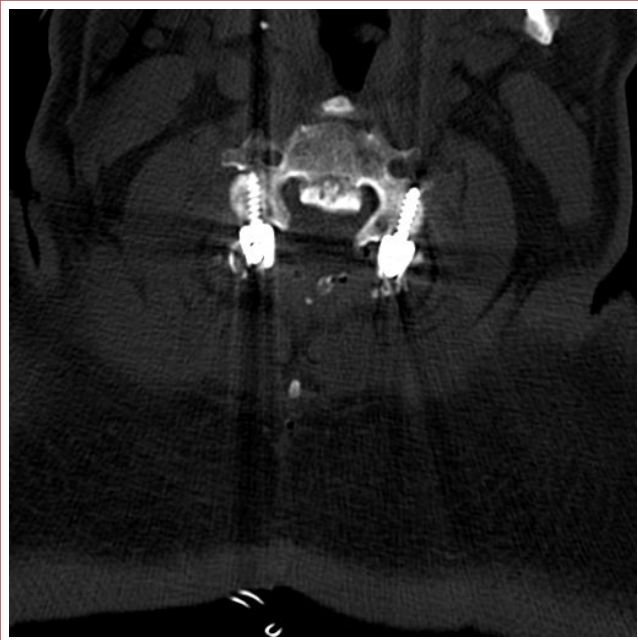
Postoperative CT axial image
